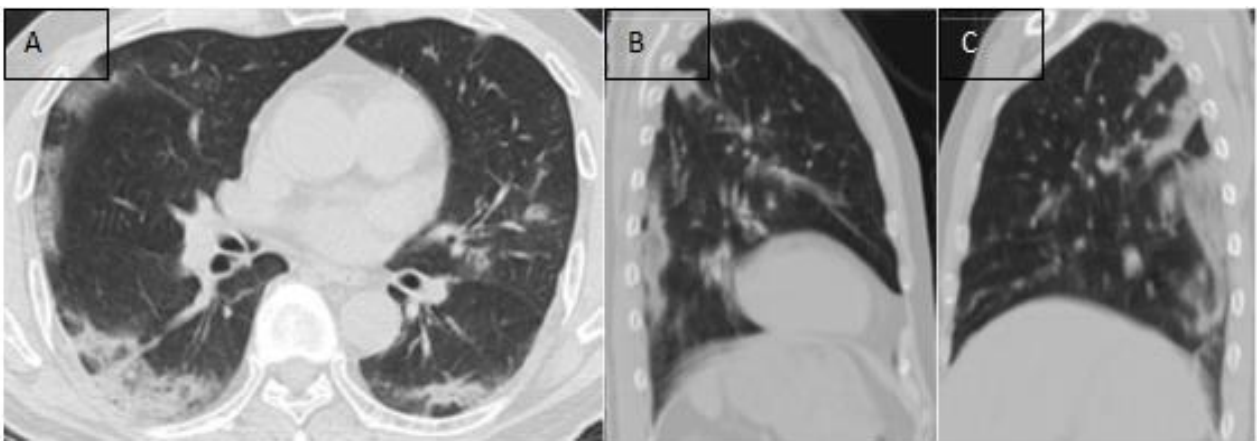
Chest CT images show peripheral/subpleural distribution (Zhao et al., 2020a).
